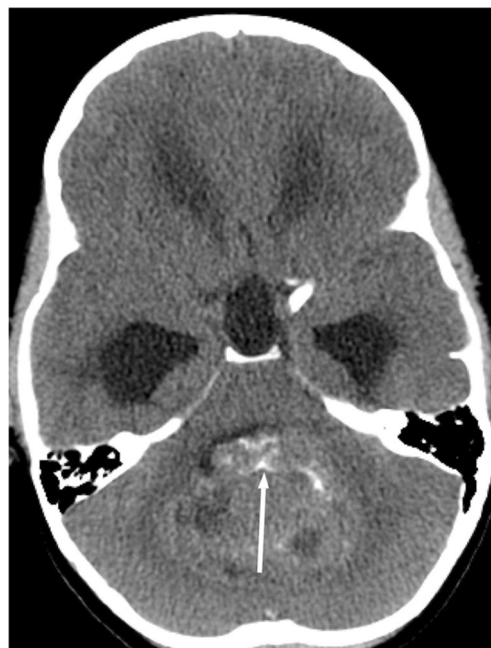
Medulloblastoma in a 5-year-old boy with an unsteady gait, headaches, nausea, vomiting and hydrocephalus. Nonenhanced CT axial image shows a heterogeneous mixed cystic and solid mass with multiple small calcification foci projecting into the 4th ventricle (*arrow*)
